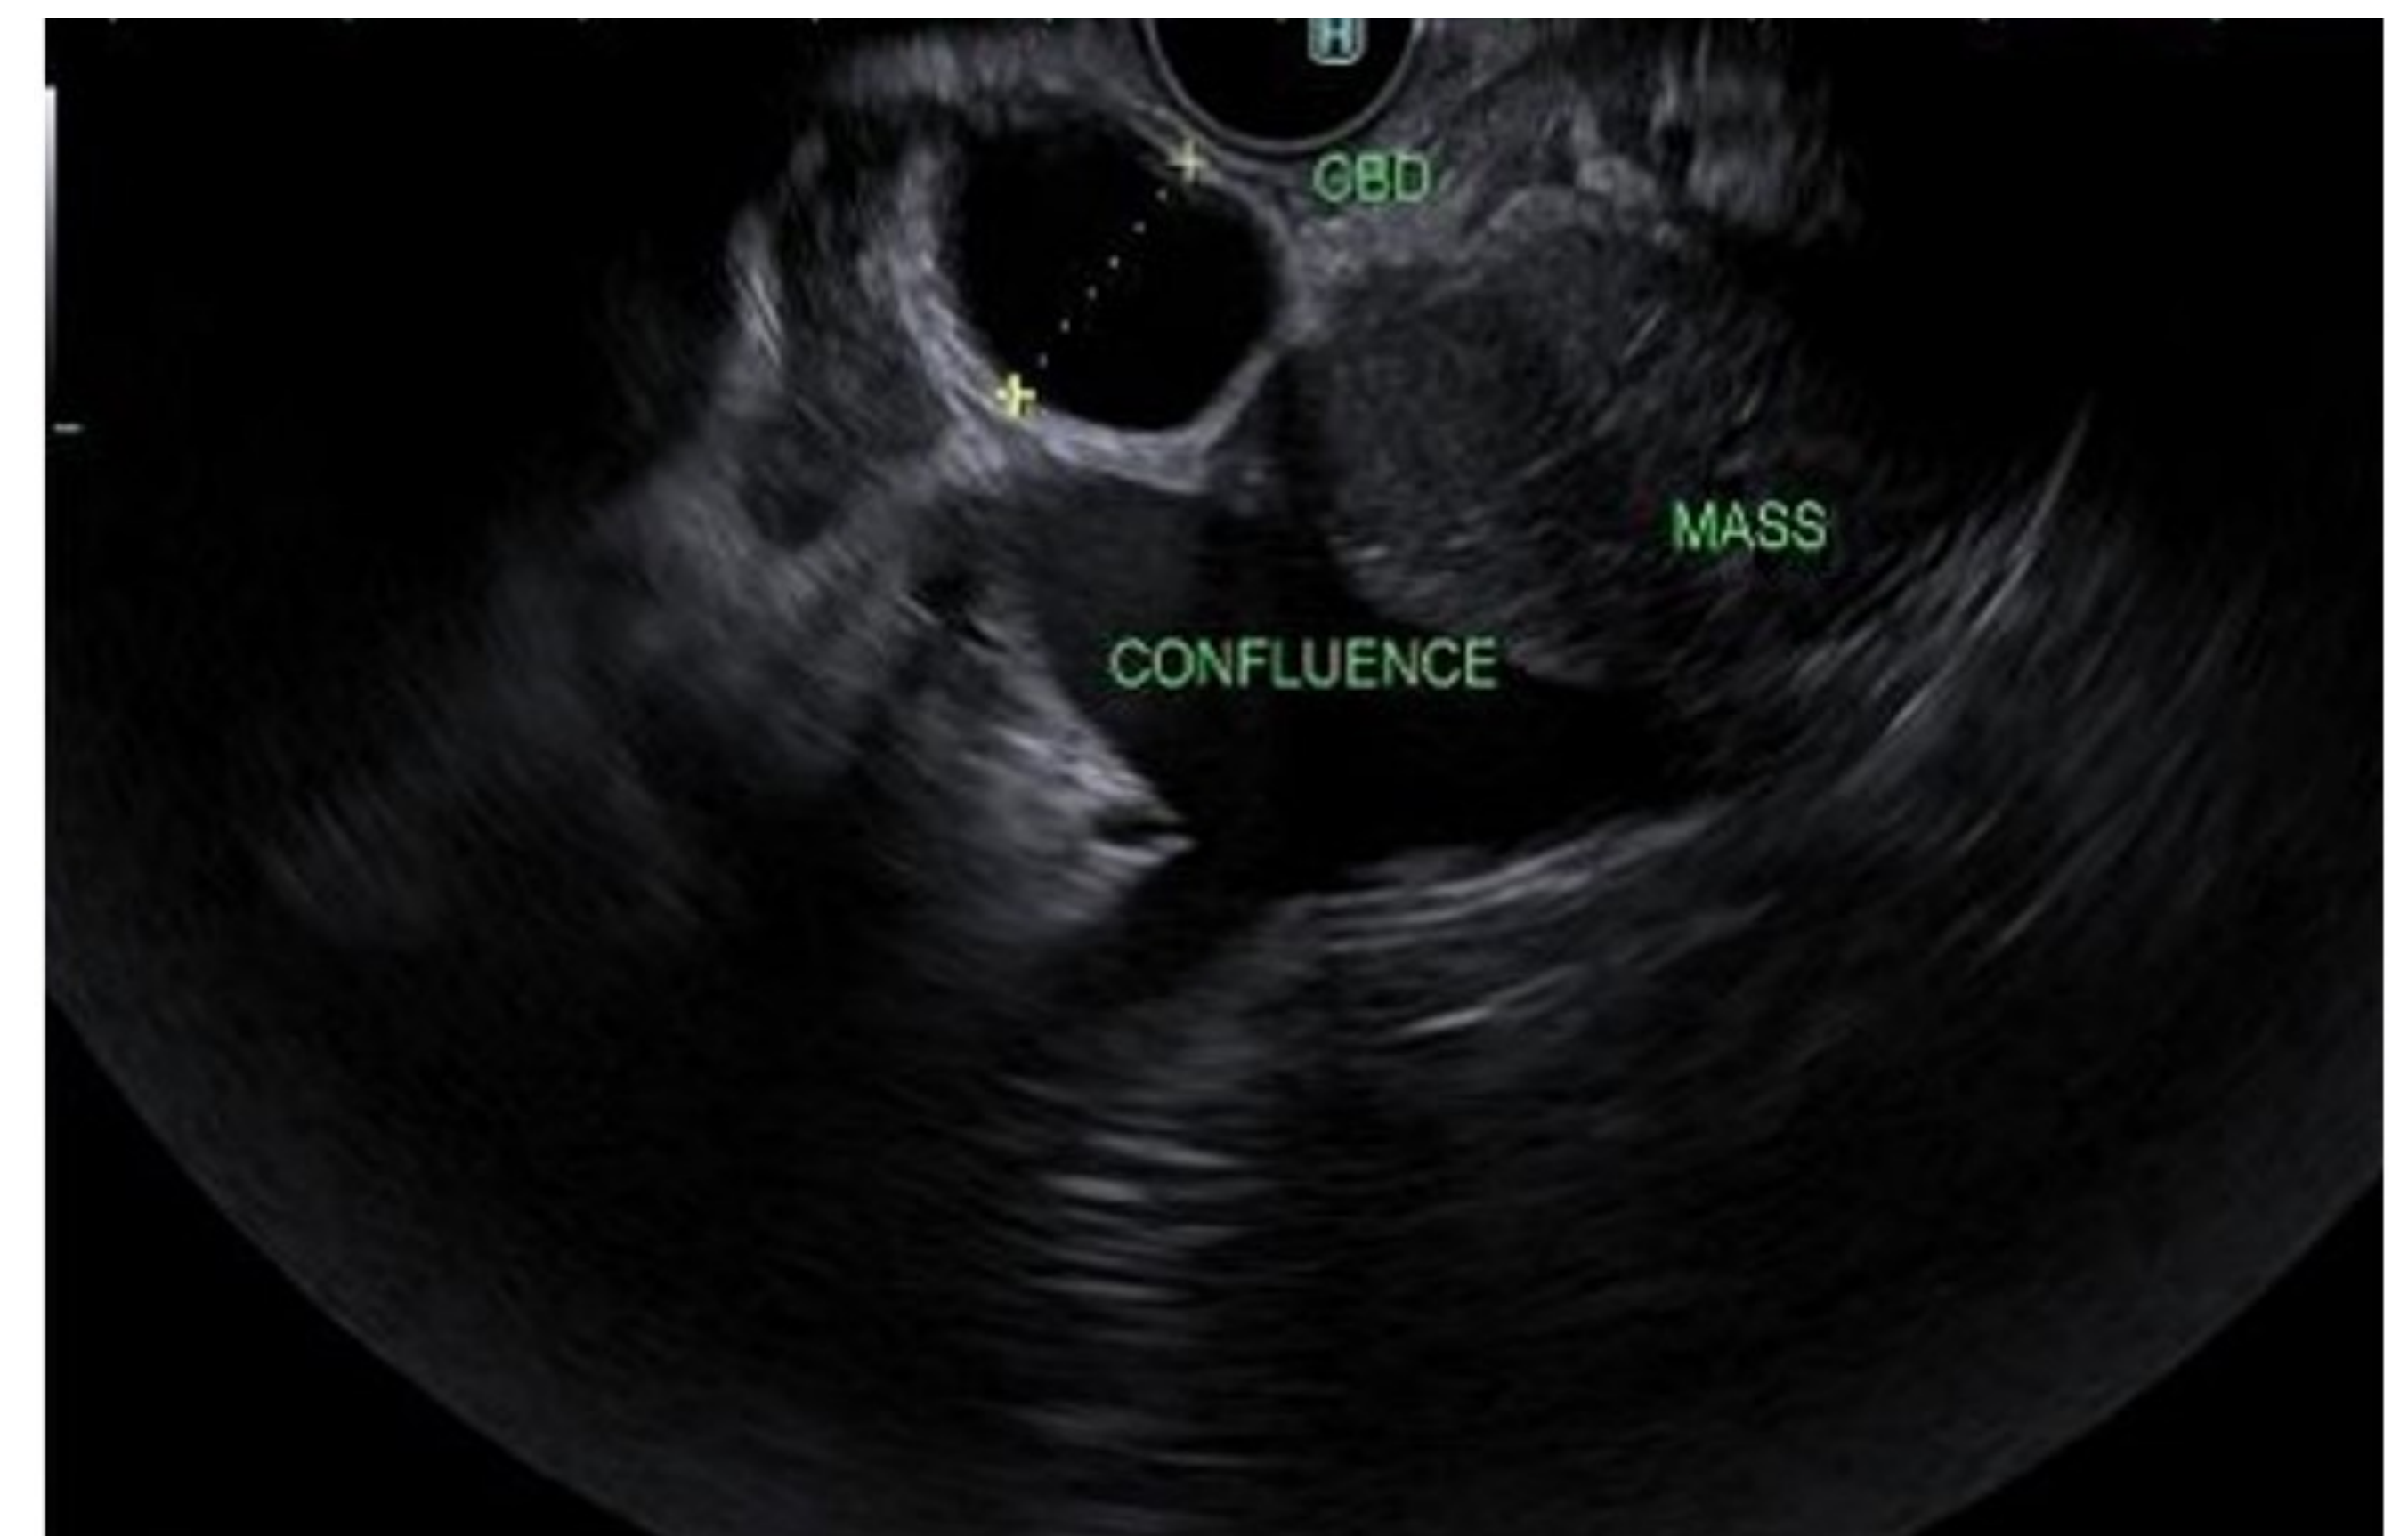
A parenchymal mass (2.2 x 1.8 cm) was noted in the head of the pancreas by endoscopic ultrasound (EUS) adjacent to the portal confluence, and the common bile duct was dilated to 12.8 mm (marked by yellow cross signs).
